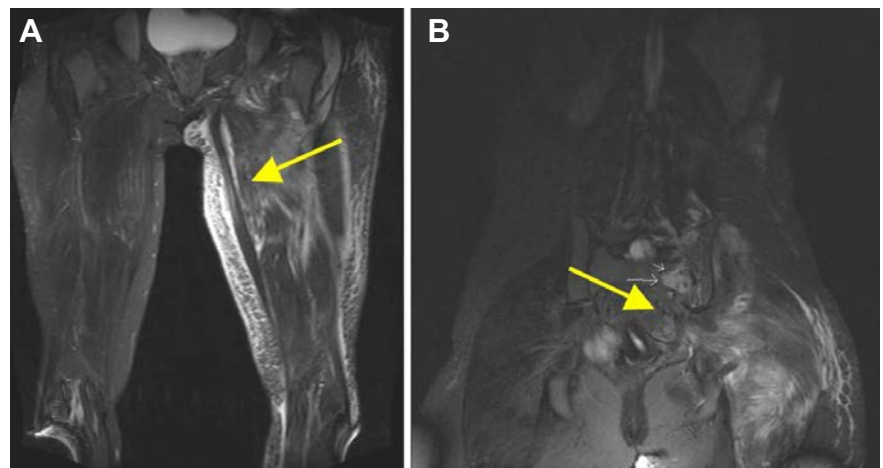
A) Necrotising fasciitis of the left thigh with enhancement of the tissue (MRI, T2, frontal); B) Abscess of the left sacro-iliac joint (MRI, T2, frontal).
